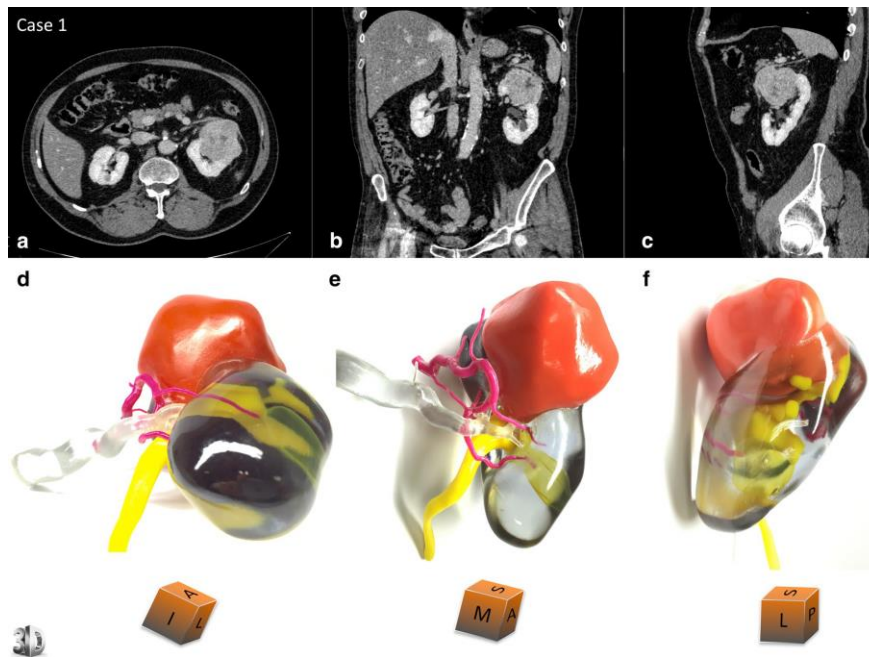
3D printed model for kidney with tumor anatomy. Comparative views of the CT scan at the nephrographic phase (a axial, b coronal and c sagittal planes) and corresponding views of the physical model (d superior and median view, e median and anterior view, f lateral view). An inferior polar cyst is also displayed on this model (translucent yellow). The cubes show the 3D printed model orientation in space [147].
